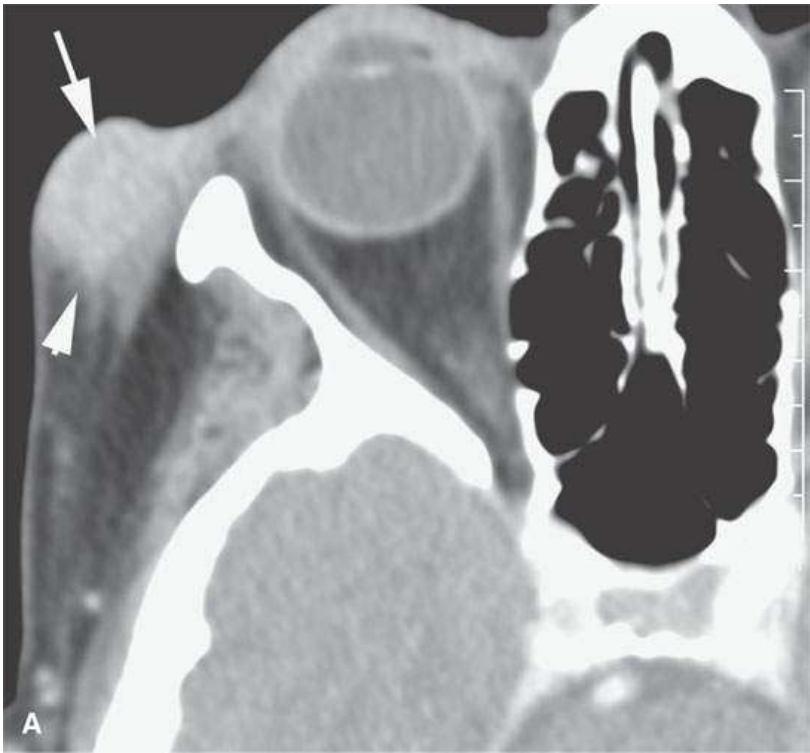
Contrast-enhanced computed tomography of a patient with a rapidly progressive malignant melanoma. The studies in (A) and (B) are only 2 months apart.
